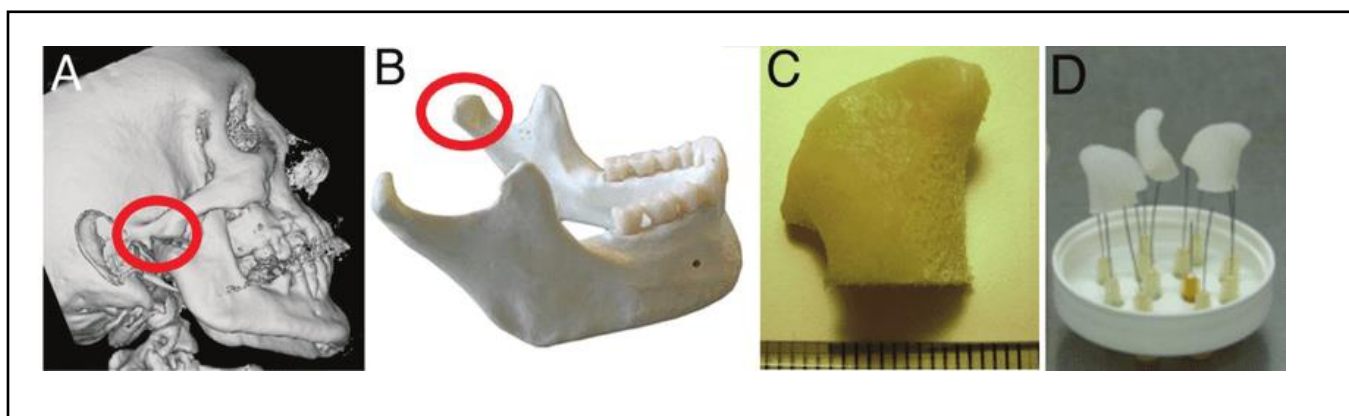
Anatomically shaped bone transplant tissue engineering. (A–C) Preparation of the scaffold. (A, B) High-resolution digital data was obtained from clinical CT scans in order to rebuild the precise geometry of human TMJ condyles. (C) These data were used to create TMJ-shaped scaffolds from entirely decellularized trabecular bone using MasterCAM software. (D) A shot depicting the complicated geometry of the final scaffolds, which varies significantly in each projection [57].
